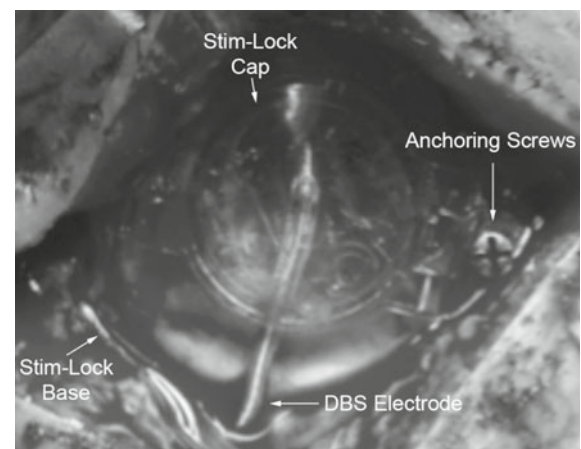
Expanded view of skull mounted fixation device interface and operative photograph demonstrating relationship of Stim-lock device and anchoring bone screws Both the DBS electrode and anchoring screws are hyper dense to brain and skull on CT and are easily segmented using iPlan Stereotaxy 2.6 (BrainLab). The DBS electrode is anchored using the Stim-lock device at the skull entry point, which can be seen in the expanded view of the fixation device interface on the left.
